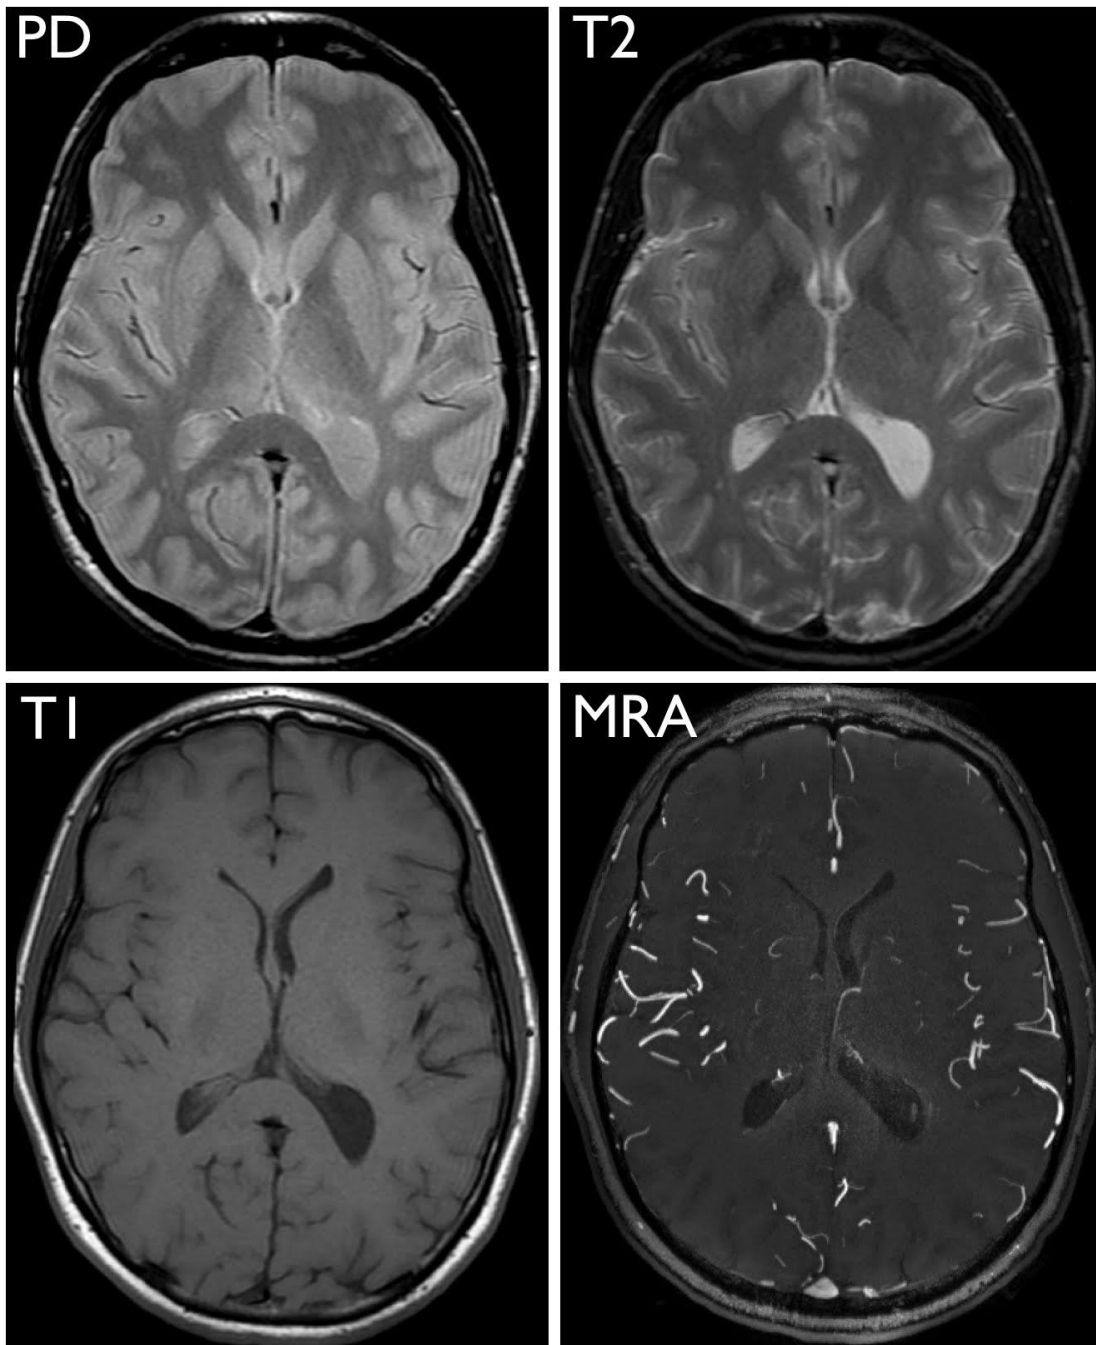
Different contrasts in MRI (<http://www.radiology.ucsf.edu/>)
